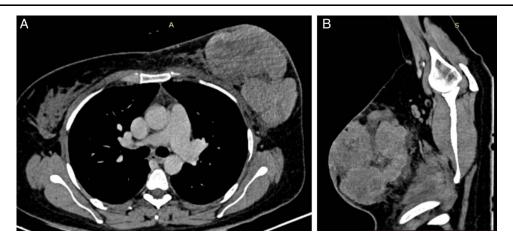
(A and B) Contrast-enhanced computed tomography (CT) revealed an asymmetric, large left breast with a heterogeneously enhancing conglomerate of multiple soft tissue density masses. The mass had an indistinct fat plane with the skin and was accompanied by skin thickening.
